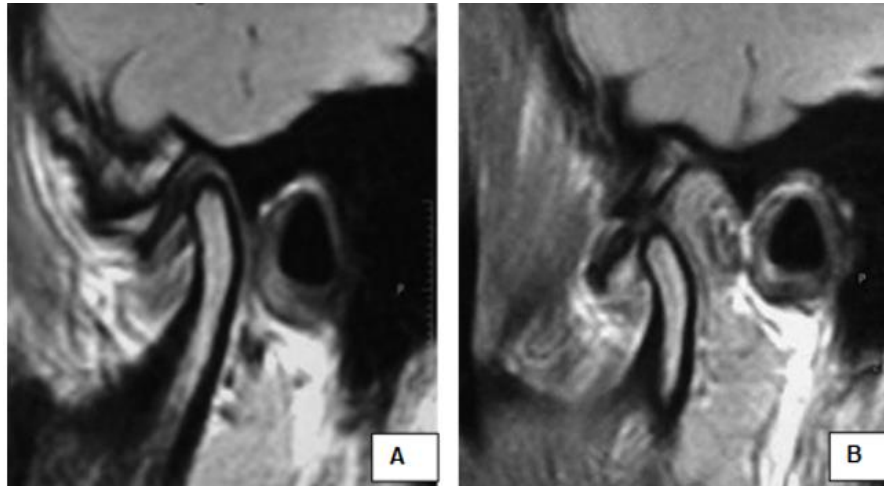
A- showing anterior disc displacement in MRI (closed mouth). B- confirming that the disc is not reducible in open position MRI
